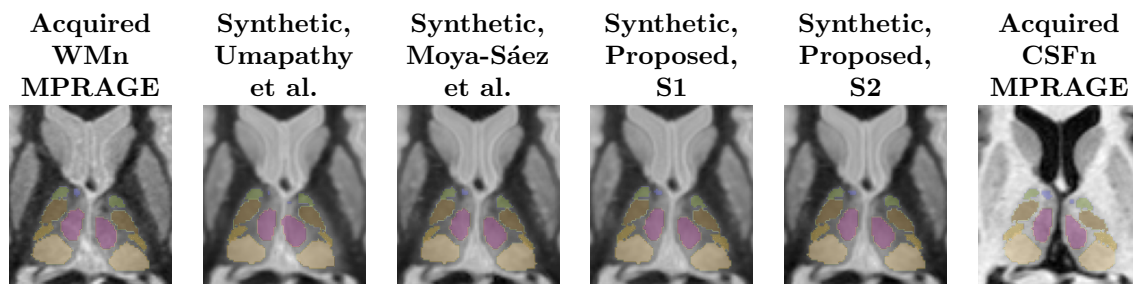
A cropped slice of the results from our segmentation experiments, overlaid on the image from which the segmentation was calculated and zoomed in on the thalamus. The first and last MR images (also shown in Fig. 1) were acquired and the rest (also shown in Fig. 3) are synthetic.
